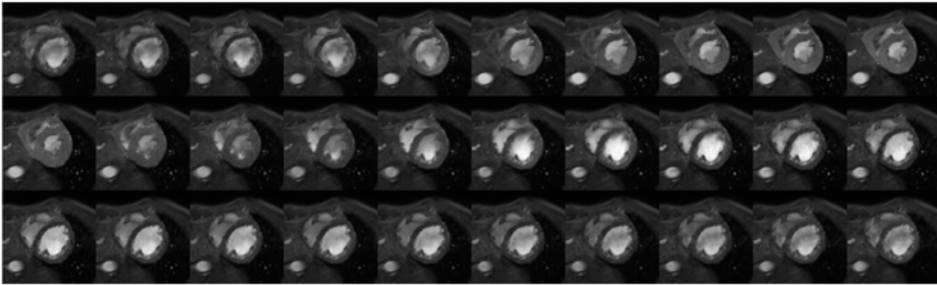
Series of 30 short-axis cinematographic MR images obtained in a healthy volunteer from the beginning of systole (top left) to end-diastole (bottom right). Images of Hans van Assen (Eindhoven University of Technology) and Jos Westenberg (Leiden University Medical Center).
